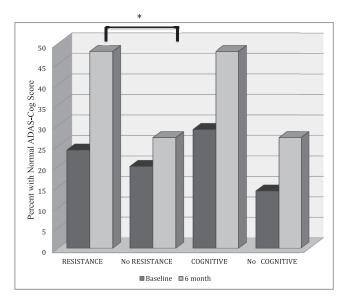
Proportion of participants with ADAS-Cog total score within normal range at baseline and after 6 months of training. *Resistance training was associated with a significantly increased proportion of participants with normal ADAS-Cog scores (increasing from 24% at baseline to 48% after training compared with 20% to 27% in the nonresistance training participants: adjusted OR (95% CIs) = 3.50 (1.18, 10.48), P < .03). By contrast, there was no significant effect of CT on ADAS-Cog status at 6 months (increasing from 29% to 48% normal) compared with noncognitive training participants (increasing from 14% to 27% normal; OR 1.00 (0.34, 2.95; P > .99).
